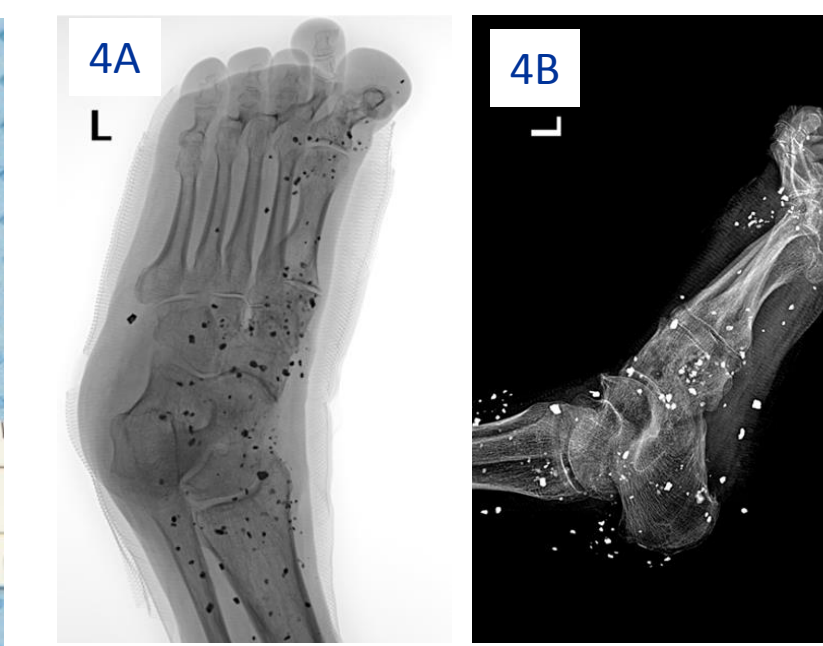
MO plain film post-op
